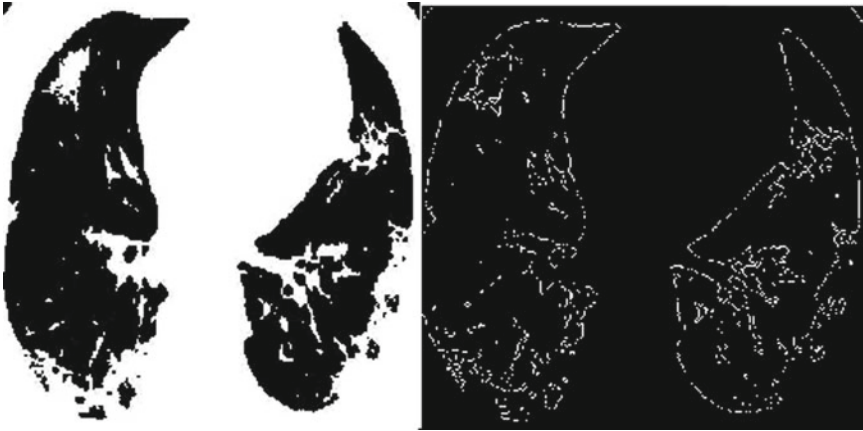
Edge descriptions for CT scan image
